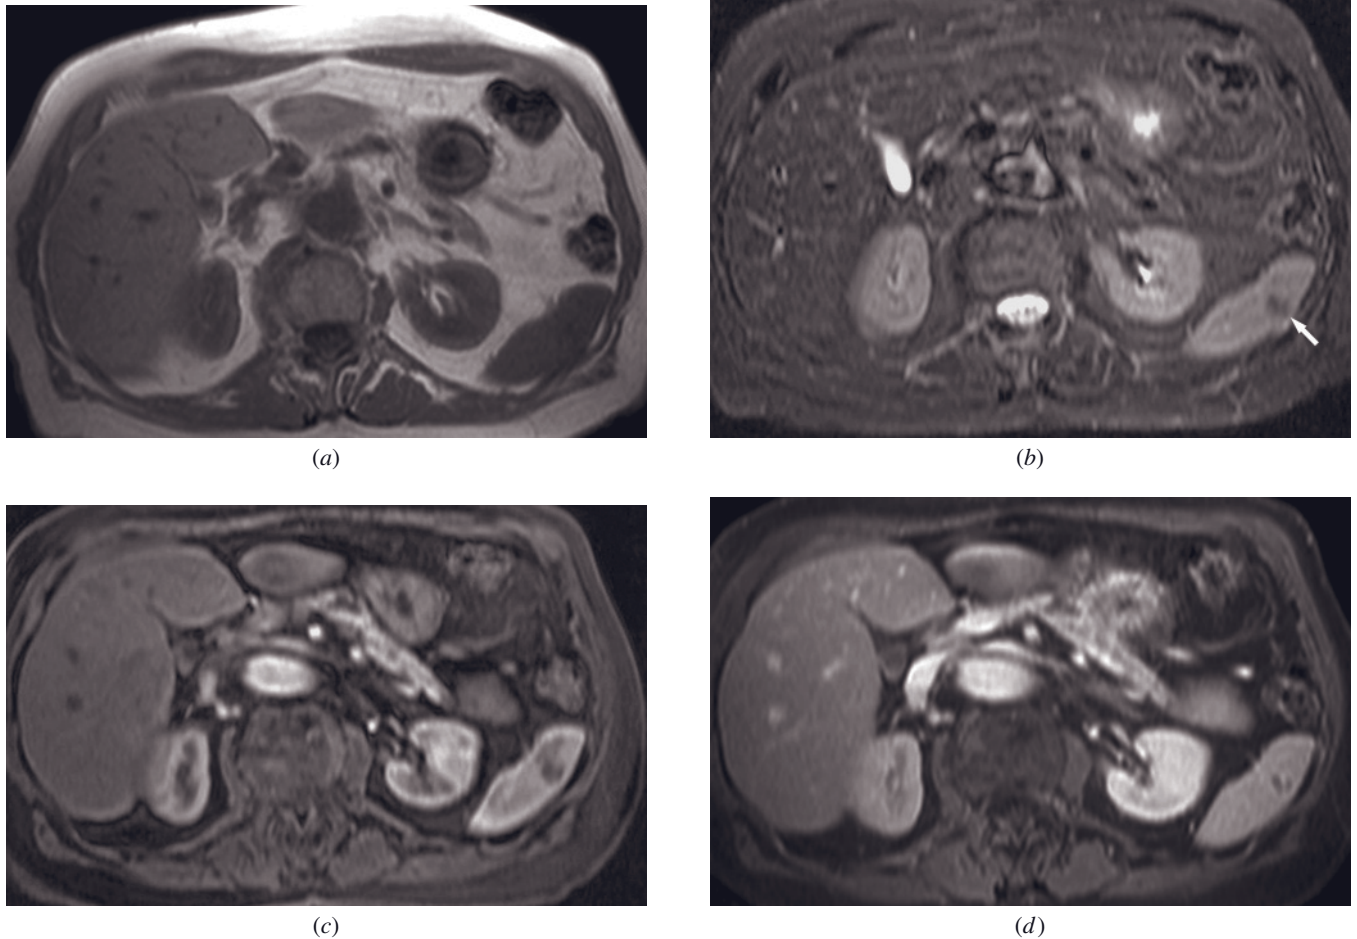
Sclerosing hemangioma. T1-weighted SGE (*a*), T2-weighted fat-suppressed single-shot echo-train spin-echo (*b*), and immediate and 90-s postgadolinium T1-weighted fat-suppressed 3D GRE (*c*, *d*) images demonstrate a 1-cm hemangioma that is isointense with spleen on the T1-weighted image (*a*) and markedly hypointense on the T2-weighted image (arrow, *b*). Peripheral nodule of enhancement is present on the early postgadolinium image (*c*), with moderate progressive enhancement on the delayed postgadolinium image (*d*). The combination of hypointensity on T2-weighted image with only moderate progression of nodular enhancement on postcontrast T1-weighted image is consistent with a sclerosing hemangioma.
